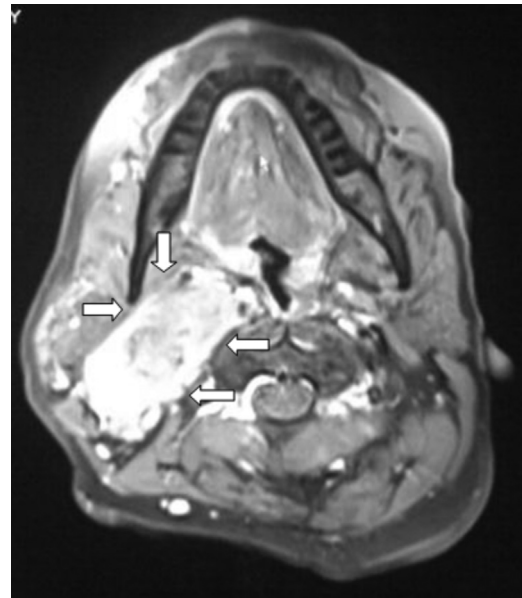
MR imaging demonstrating a soft tissue mass compressing adjacent structures.
